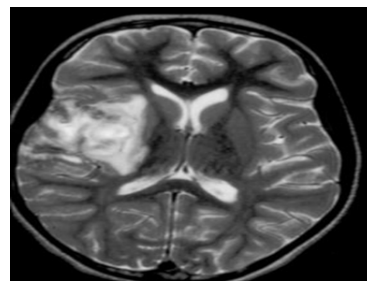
T2-weighted magnetic resonance image of a right parietal tuberculoma. Note the low-signal-intensity rim of the lesion and the surrounding hyperintense vasogenic edema.
